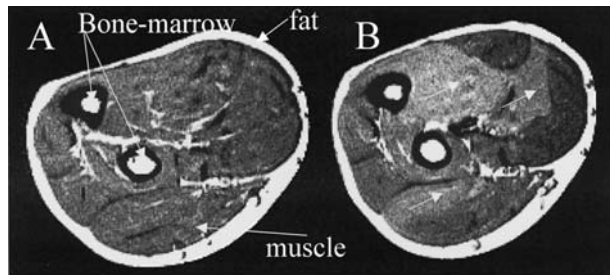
Typical T2-weighted ^1H MR images representing transverse sections of the forearm recorded at rest (A) and after a finger-flexion exercise (B). Areas with a higher contrast on image B indicate activated muscles during exercise.
